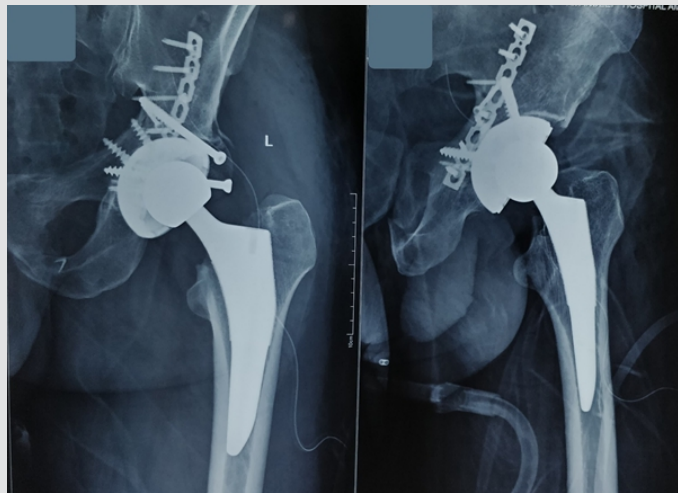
Immediate post-operative radiograph after acute primary uncemented total hip arthroplasty of the left hip with acetabular reconstruction using femoral head structural autograft showing anatomical reduction of the acetabular fracture along with satisfactory alignment and positioning of the femoral and acetabular components.
